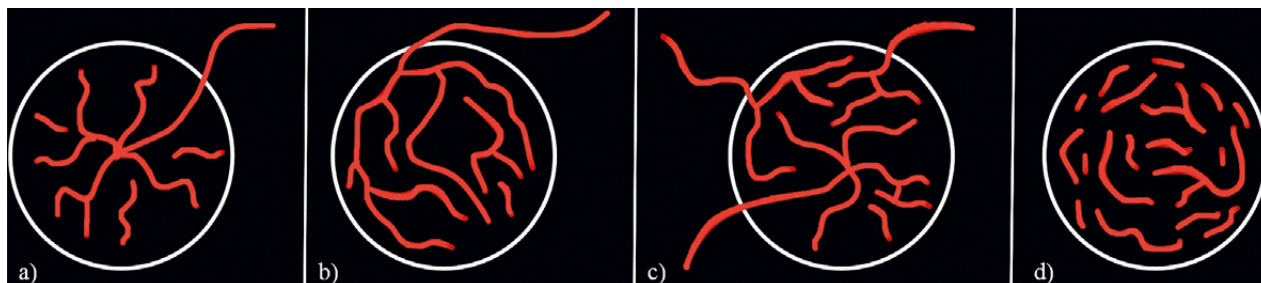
Classification of FNH by CEUS [14,97,105]. Type I (85%): classical type with spoke-wheel sign (SWS). Vessels run to the center using colour coded doppler ultrasound with or without a central scar (a). In the eccentric type II the central point of the vessel star is shifted to the edge. Type III (15%): Teleangiectatic “atypical” FNH, peliotic sinusoid (b) [106]. Type IV shows homogenous enhancement.
